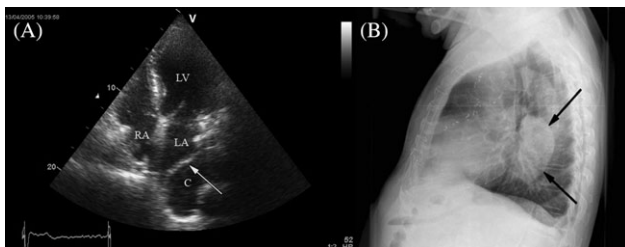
Analysis with transthoracic echocardiography (A) revealed an echolucent mass impressing the left atrium (arrow) in an asymptomatic patient. LA, left atrium; RA, right atrium; LV, left ventricle; c, echolucent mass. Later performed chest X-ray (B) shows a retrocardiac mass (arrow). Biopsy identified the structure as a bronchogenic cyst.
